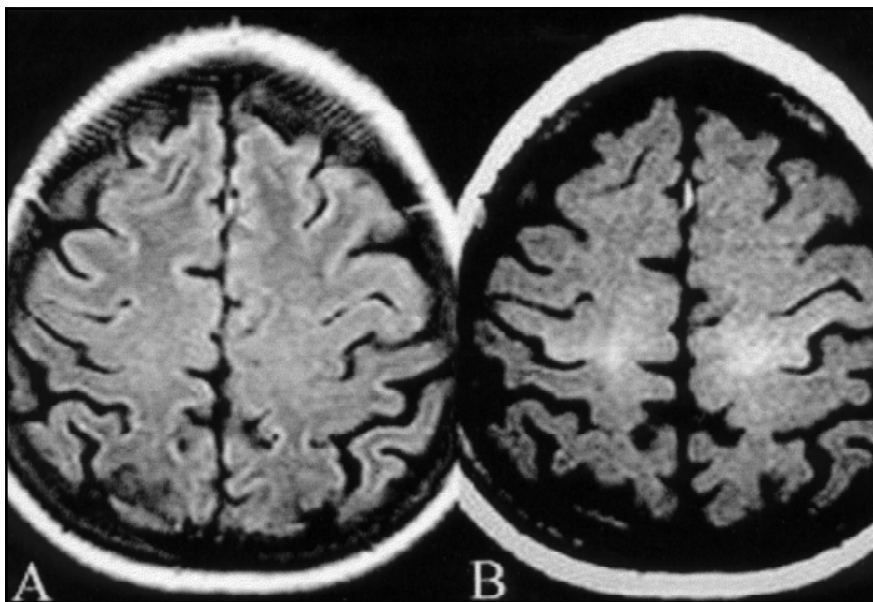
ALS patient. A- Axial FLAIR without abnormal findings. B- Axial T1/SE/MT showing the alterations more conspicuously than on FLAIR.
